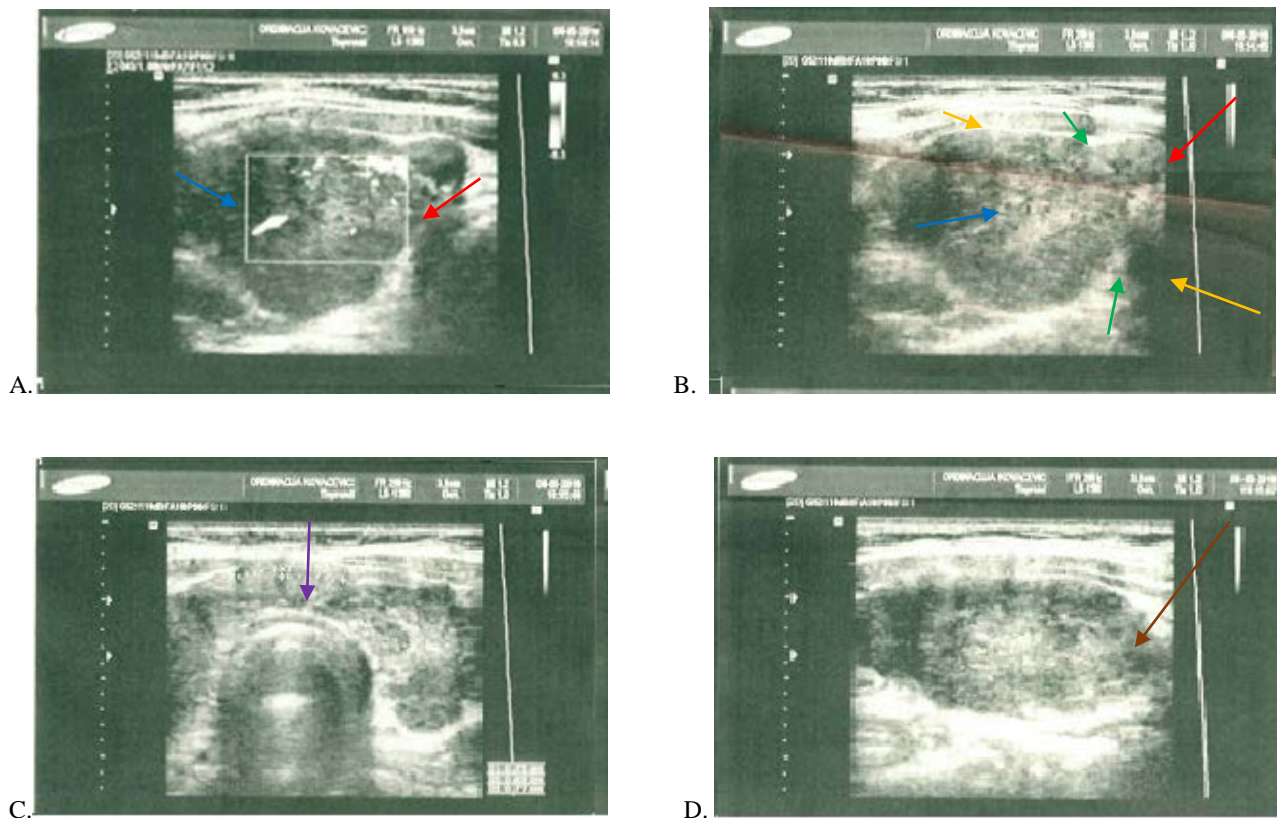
An echocardiogram of the thyroid gland: A) and B) the right lobe (indicated by red arrows); the right lobe has unclear boundaries (yellow arrows) from the surrounding tissue, heteroechoogenic parenchyma with pronounced hypoechogenicity (marked with blue arrows) and calcifications (marked with green arrows) in the posterior aspect; C) The isthmic part (indicated by purple arrow); D) The left lobe (indicated by brown arrow) is pseudonodularly altered.
